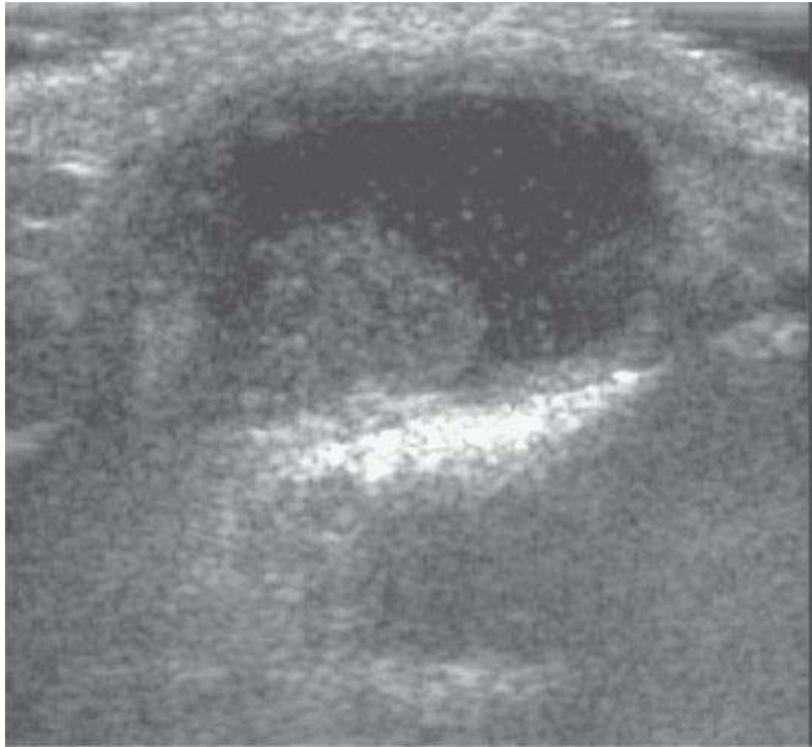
Ultrasound of a pediatric patient believed to have a thyroglossal duct cyst. The study showed a cyst and a nodule but was not anatomically complete enough to confirm the diagnosis of a thyroglossal duct cyst. In essence, these were resources and time that might have been better spent.
